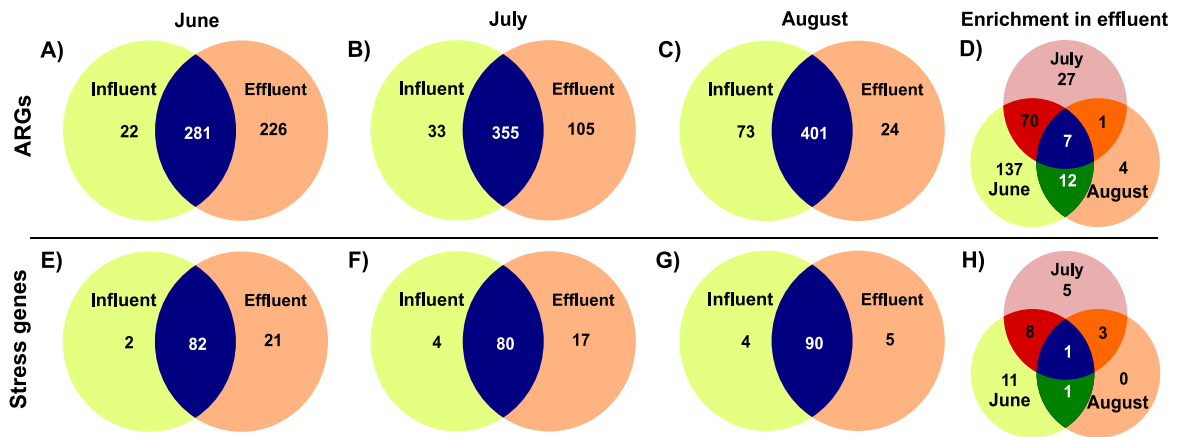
Share and unique ARGs (A-C) and stress genes (E-G) between the influent and effluent for the CST-household tank (CT-P3) with accessible influent sample for the three sampling months (June, July, August); and number of shared and unique ARGs (D) and stress genes (H) enriched in the effluent of the CST-household tank (CT-P3) between the three sampling months (June, July, August).
